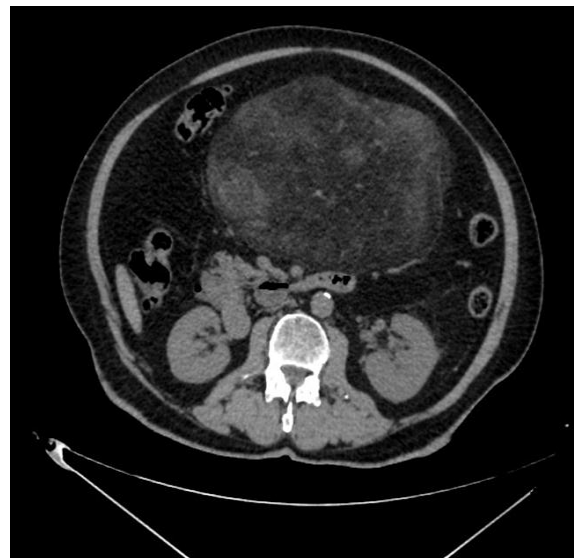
CT scan abdomen- Retroperitoneal liposarcoma
